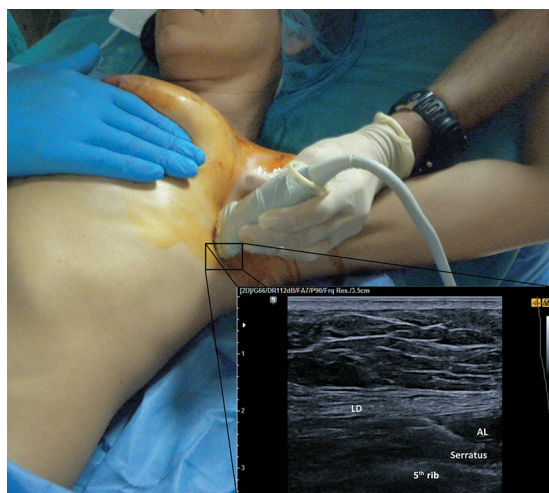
Ultrasound-guided Serratus Plane Block. LD: latissimus dorsi muscle; AL: local anesthetic; Serratus: serratus anterior muscle; 5th rib: fifth rib.
